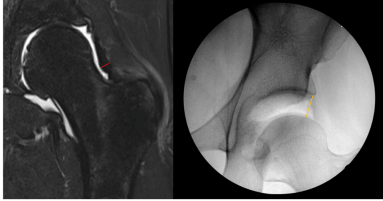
Left hip T2-weighted magnetic resonance arthrogram (Left) and intraoperative fluoroscopic image at 100 pounds axial traction (Right). The red line represents the measurement of the zona orbicularis (Left) while the yellow line represents the joint space measurement in response to axial traction (Right).
